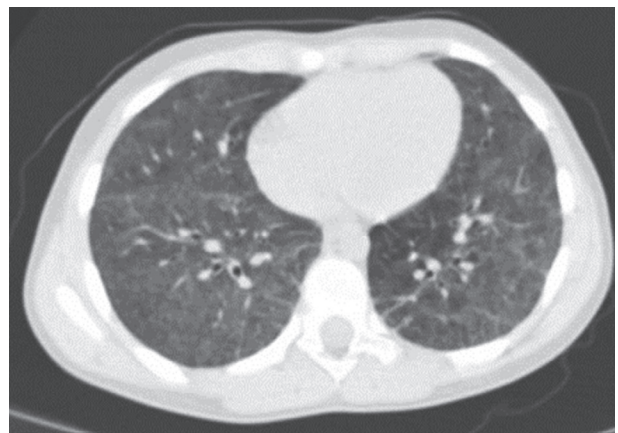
Chest high-resolution computed tomography showing areas of a ground glass pattern and subpleural reticular opacities.
